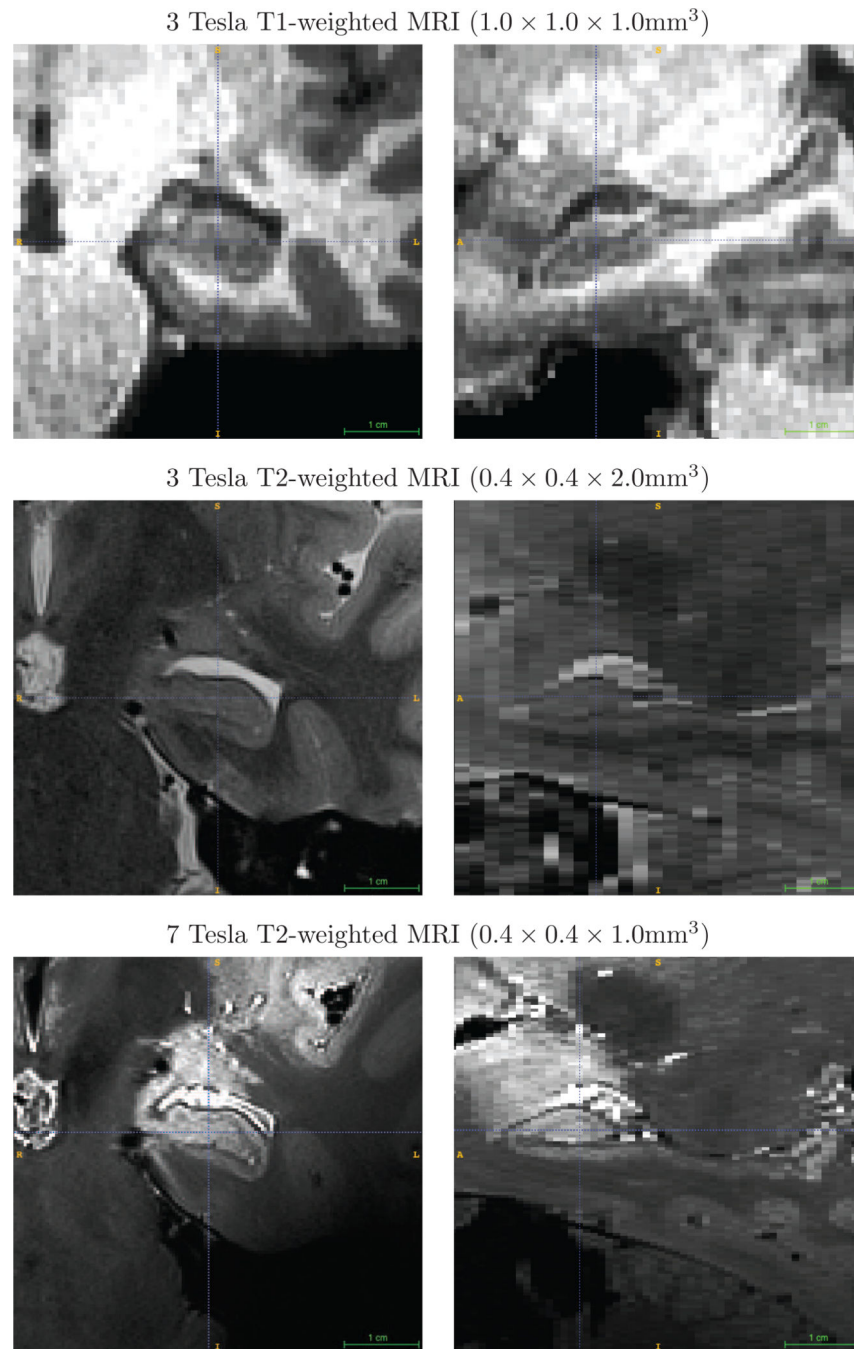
Coronal/oblique coronal (left) and sagittal (right) slices through the left hippocampus in the three different MRI scans used in this study. The blue crosshair points to the same anatomical location in all three images. Note that the T2-weighted 3T and 7T scans are acquired in an oblique coronal plane roughly orthogonal to the hippocampal main axis, whereas the T1-weighted scan is acquired roughly orthogonal to the AC-PC line. Thus, away from the blue crosshair, the anatomy seen in the coronal T1-weighted scan is not the same as in the T2-weighted scans.
